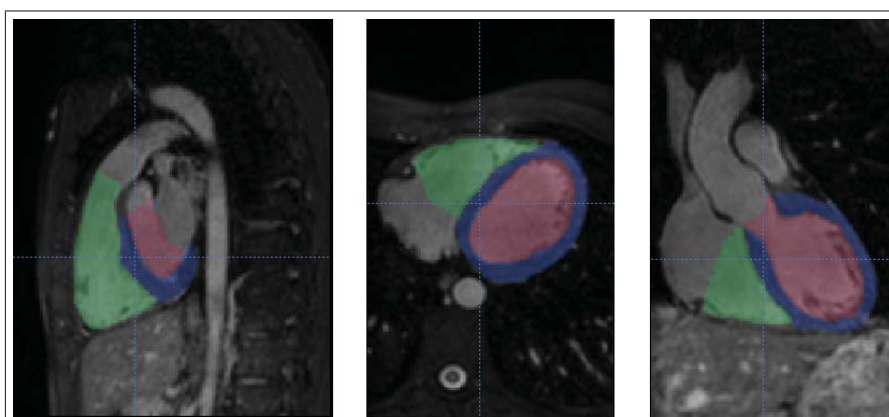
Atlas image and the ventricle segmentation labels superimposed on the MR image.
